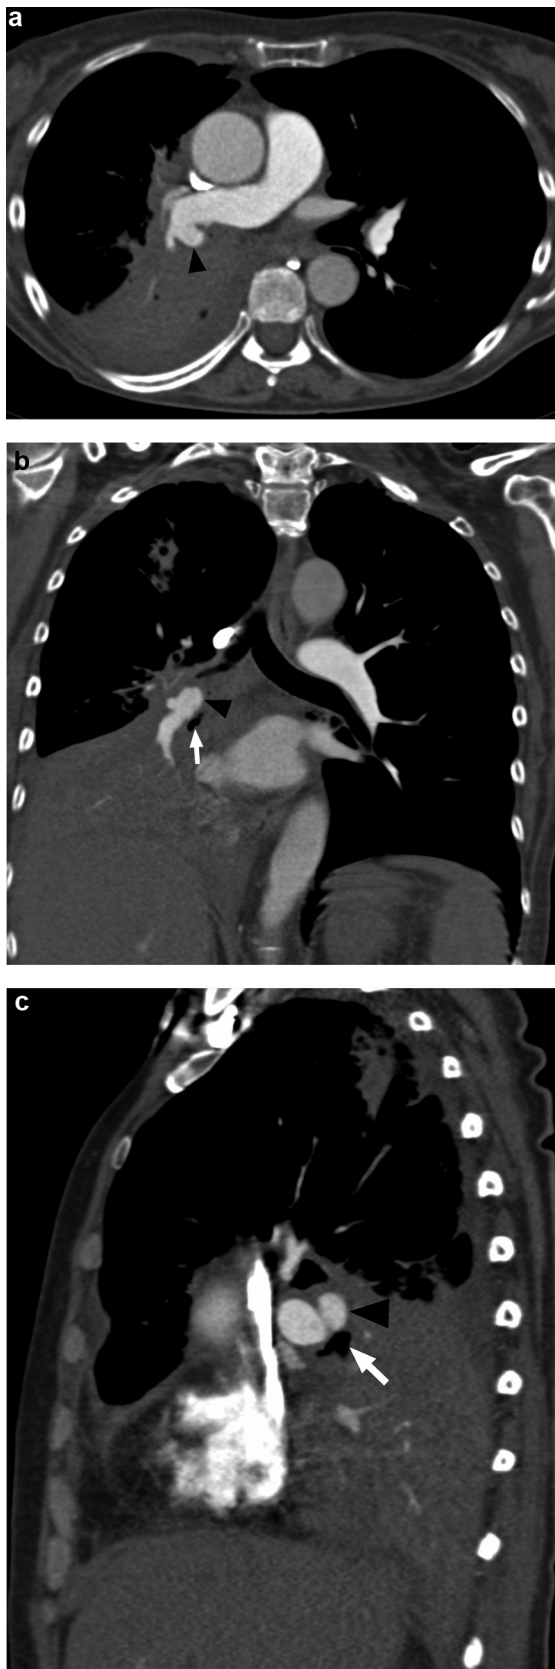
Contrast-enhanced multidetector computed tomography, depicting a right descending interlobar artery aneurysm (black arrowheads) protruding into the right intermediary bronchus (small white arrow), in a patient with a history of squamous cell carcinoma and hilar lymph node treated with stereotactic irradiation. a: axial view; b: coronal view; c: right sagittal view.
